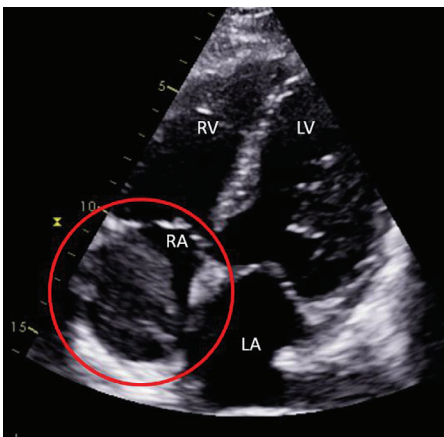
Apical 4-chamber view of transthoracic echocardiogram. The echodense mass is highlighted with the red circle.
